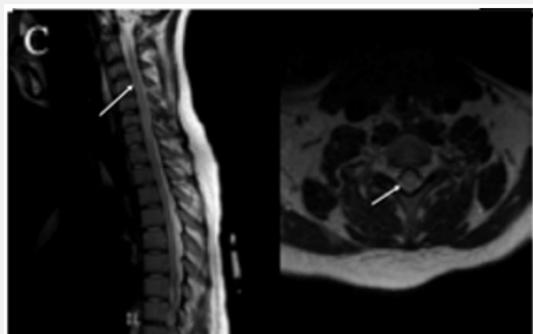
MRI of cervical/thoracic spine showing hyperintensities involving the gray matter and anterior horn cells.
